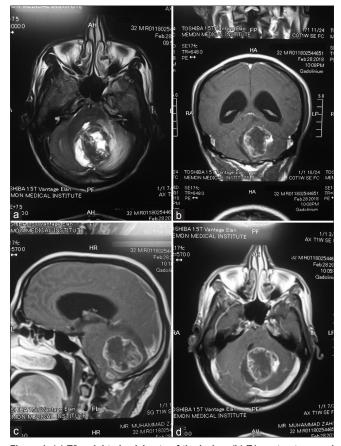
(a) T2-weighted axial cuts of the lesion, (b) T1 contrast coronal cuts of the lesion, (c) T1 contrast sagittal cuts of the lesion, (d) T1 contrast axial cuts of the lesion
